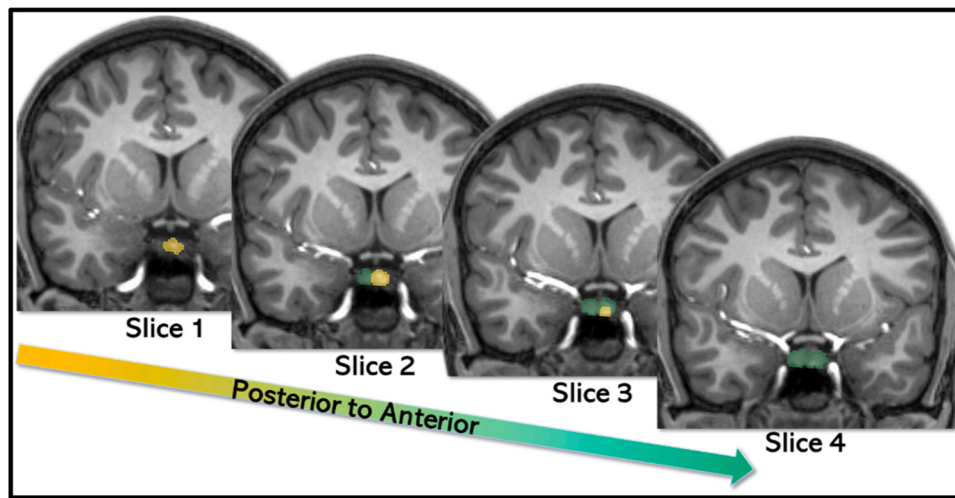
Slice-by-slice example of a manually traced pituitary gland. A set of T1-weighted images in the coronal view from a representative participant is shown across multiple slices proceeding from posterior to anterior. The anterior pituitary gland (PG) is shown in teal/green and the posterior PG shown in yellow.
